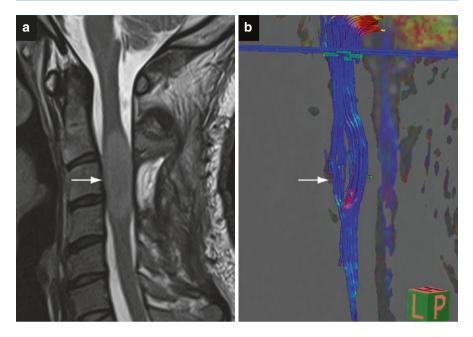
DTI tractography in the spinal cord. (a) T2W MRI demonstrates an expansile mildly T2 high signal astrocytoma in the cervical cord at the level of C3. (b) DTI tractography demonstrates lateral displacement of the white matter tracts around the tumor
